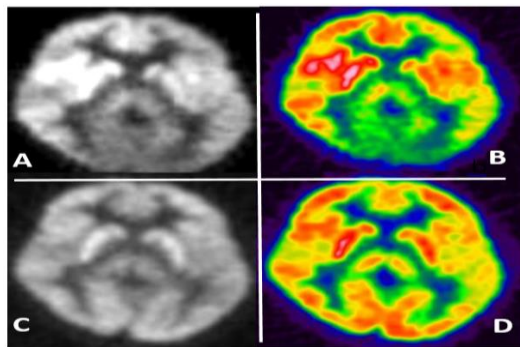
Brain 18F-FDG PET on days 5 (A/B) and 30 (C/D)
